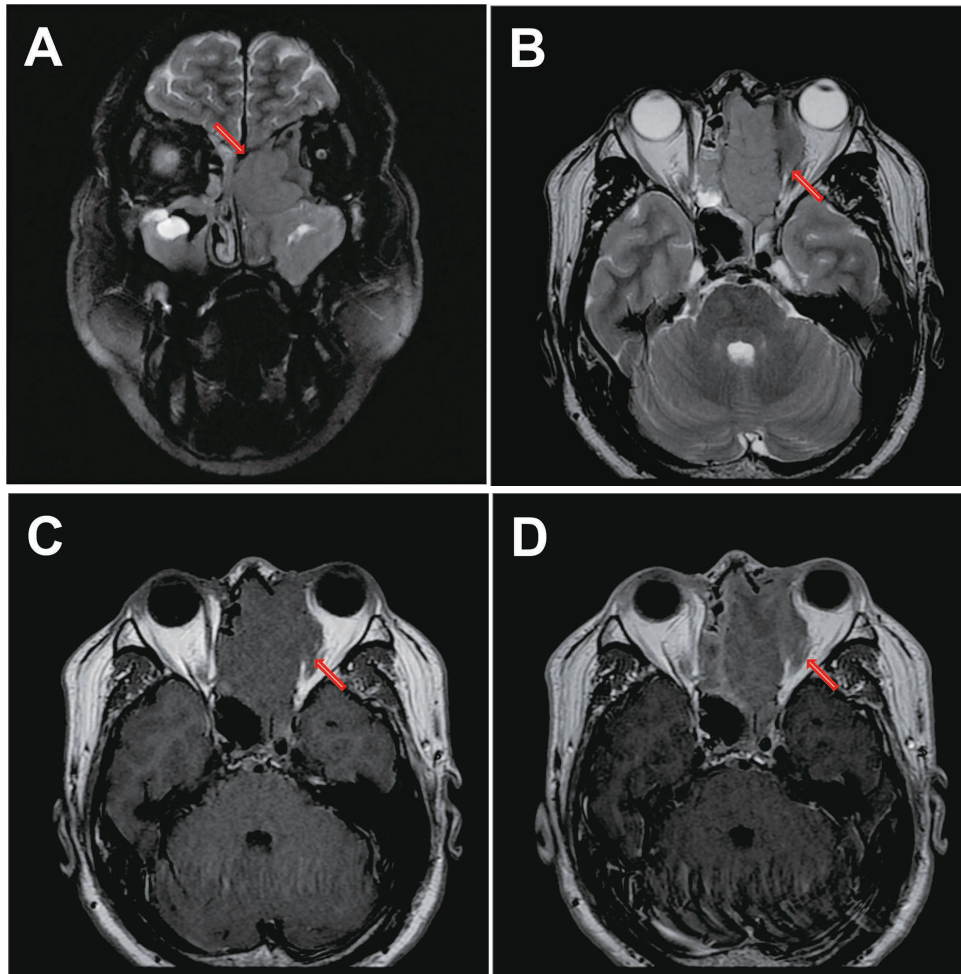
MR images of the paranasal sinuses. Magnetic resonance image showing a left ethmoidal mass (arrows) involving the maxillary sinus, the orbit, the right paranasal sinuses, and the skull base (A: coronal T2-weighted image, B: axial T2-weighted image, C: axial T1-weighted image, D: axial T1-weighted image with gadolinium).
